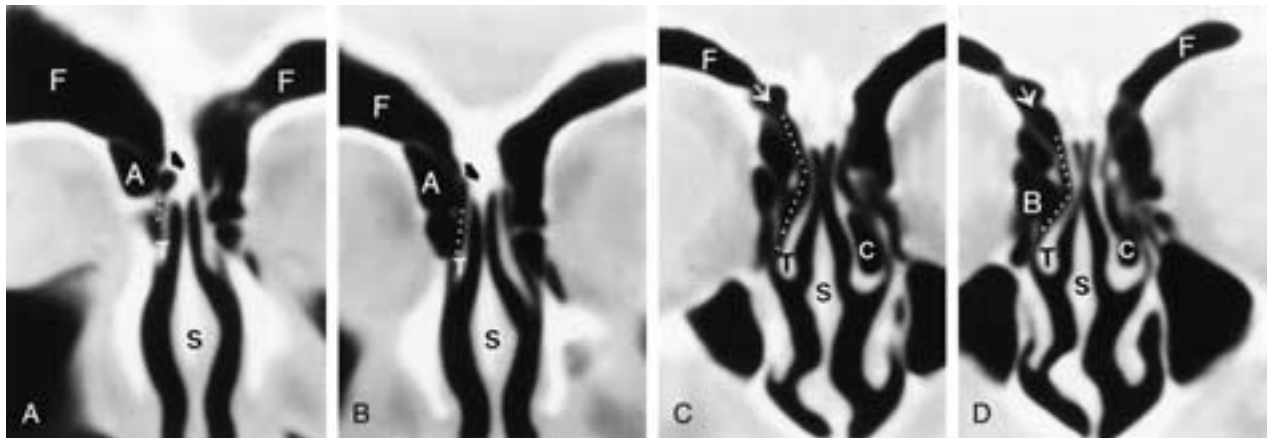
Anatomy of the frontal sinus. Coronal CT images of the frontal sinuses from anterior (A) to posterior (D) show the relationship between the frontal sinus (F) and the middle meatus (dotted line). Note that there is a bony strut (heavy black arrow in A and B) separating the frontal sinus and the anterior middle meatus. This separation is lost on the more posterior images (C and D) revealing the position of the frontal recess (white arrow). Note the position of the frontal cell (A) and its relationship to the frontal recess. Nasal septum (S), ethmoid bulla (B), middle turbinate (T), and concha bullosa (C).
